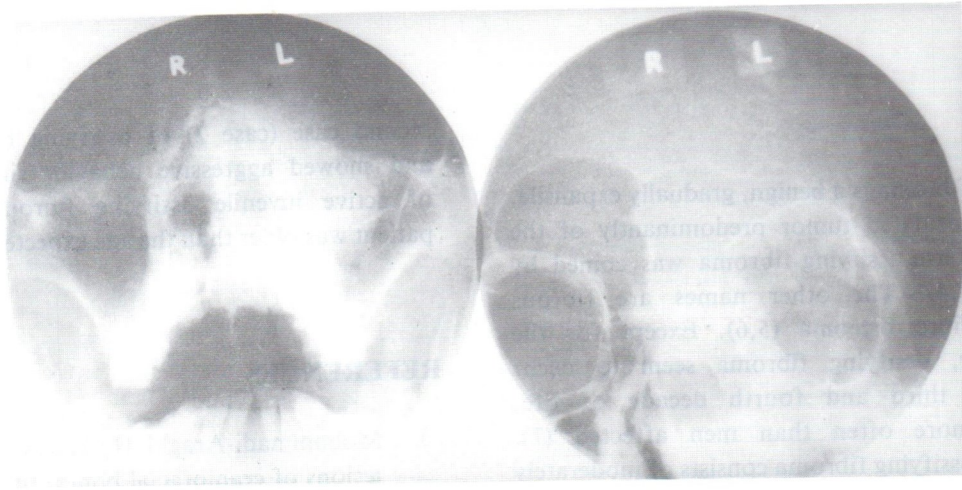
Case 3. Plain film of the paranasal sinuses showed an expanding lesion in the left nasal cavity, left ethmoid sinus with haziness of left nasal cavity, left maxillary sinus, left ethmoid sinus, medial left orbital cavity and left frontal sinus. The margin of the lesion was well defined.
